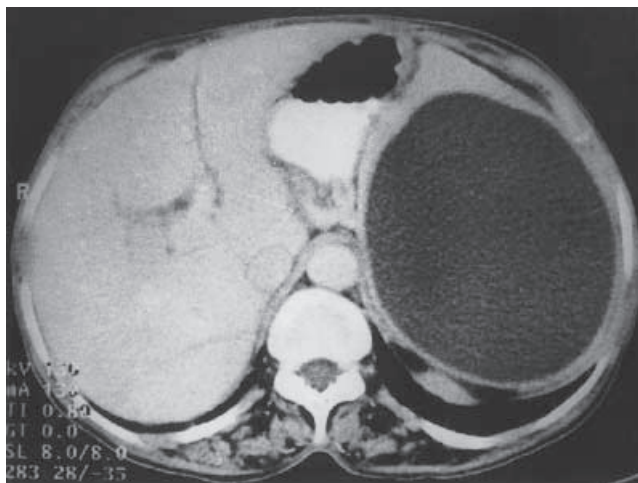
Computed tomography scan showing a splenic hydatid cyst
